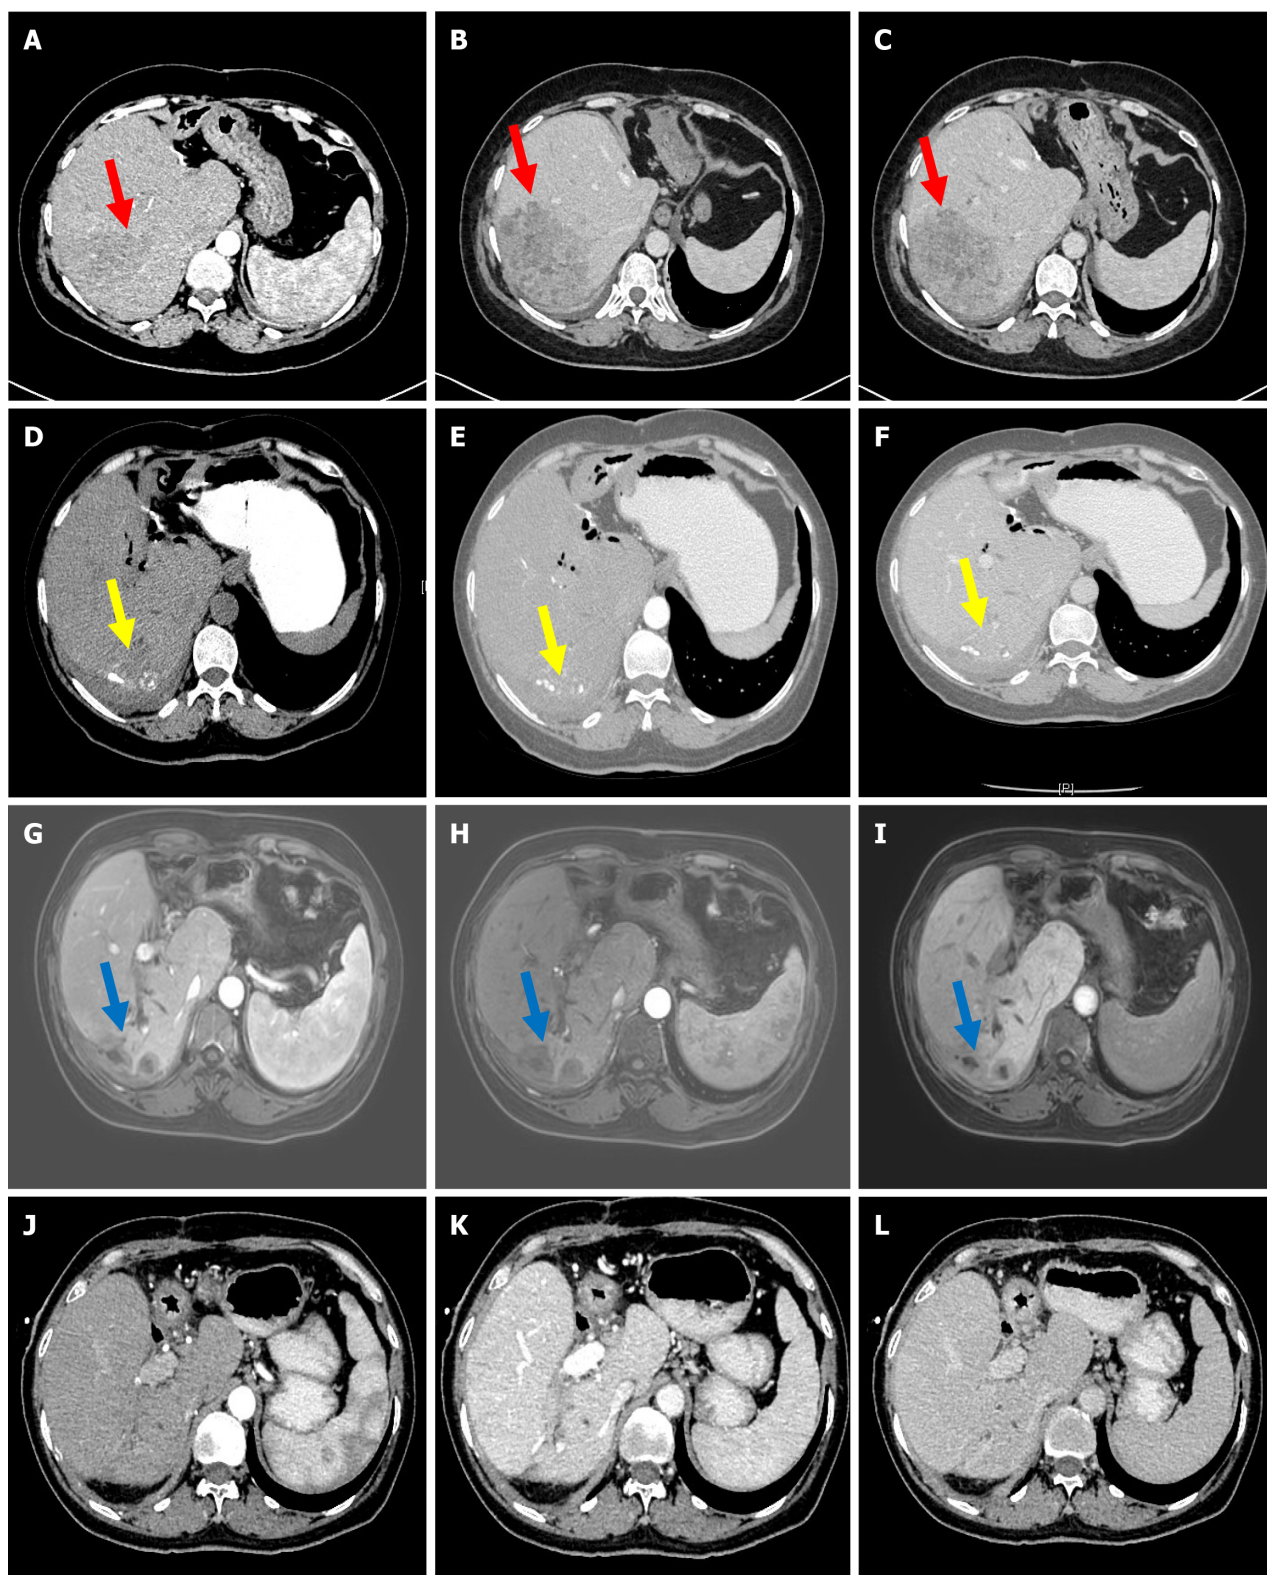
Radiological images of the patient before and after conversion therapy. A-C: computed tomography (CT) examination shows that the tumor is in the right lobe of the liver before conversion therapy; D-F: CT and magnetic resonance imaging; G-I: Examinations both indicate a decreased tumor in the right lobe of the liver before surgery; J-L: Seven months after surgery, no recurrence or metastasis was observed under the CT. The red, yellow, and blue arrows all head towards the tumor.
